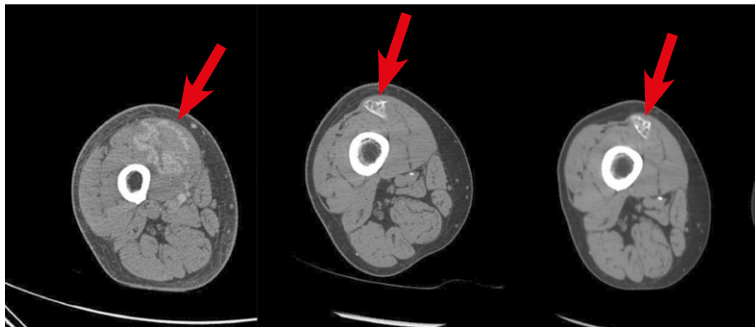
Progression of Heterotopic Ossification from presentation (left), 4 months (middle), and 8 months (right). Axial CT with contrast depicts initial hyperemia with increasing calcification at the site of injury with eventual outer cortical and inner cancellous bone formation.
